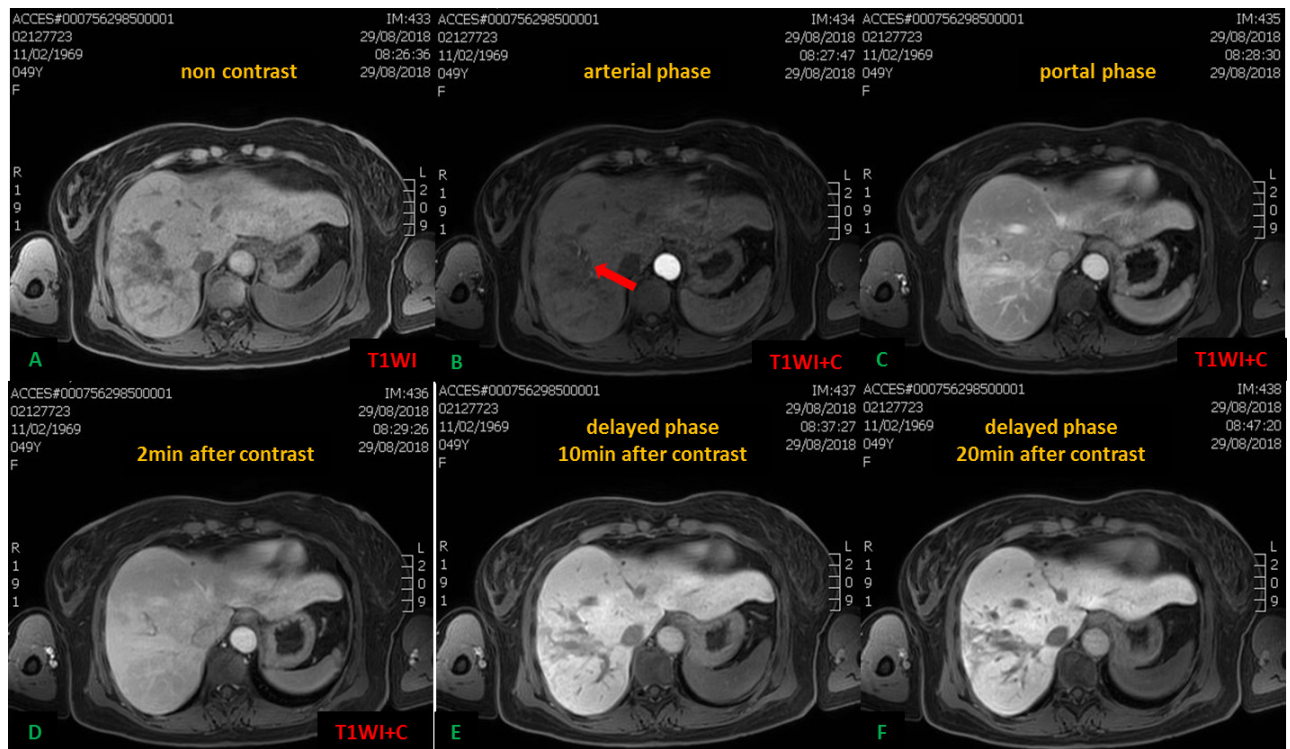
Dynamic contrast MRI of the previous lesion with the use of a hepatobiliary contrast agent. A. Fat-saturated, non-contrast T1WI shows a wedge-shaped area of low signal intensity in the right liver lobe. B. There is no contrast enhancement on the early arterial phase. Notice the small arterial branches within the lesion (red arrow). C,D. Enhancement of the region on the portal venous phase and maintained 2min after contrast enhancement. E,F. Wash out, that is no enhancement of the lesion on the delayed phase 10min and 20min after contrast enhancement. Biopsy showed inflammatory cell infiltrates and hepatocellular necrosis indicating active inflammation.
